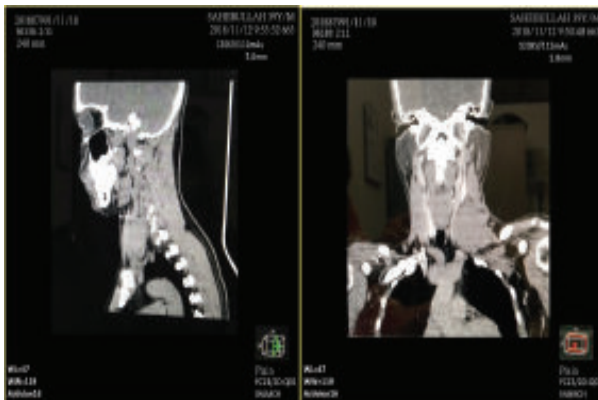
Post-contrast sagittal and coronal CT scans showing left cervical lymphadenopathy.
